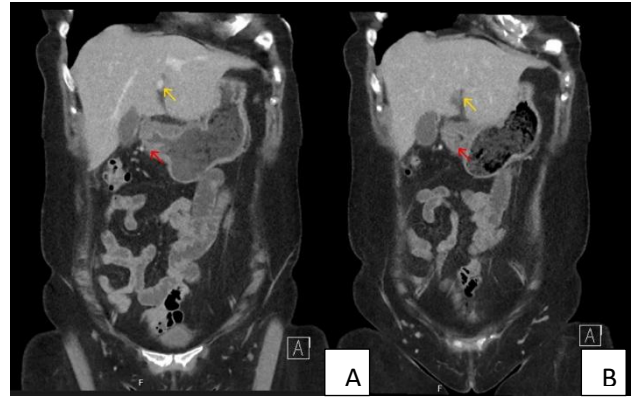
(A and B): CT abdomen pelvis with portal venous contrast; coronal slices demonstrating the recanalised umbilical vein with thrombus (yellow arrow), and thickening of the gastrum antrum (red arrow).
